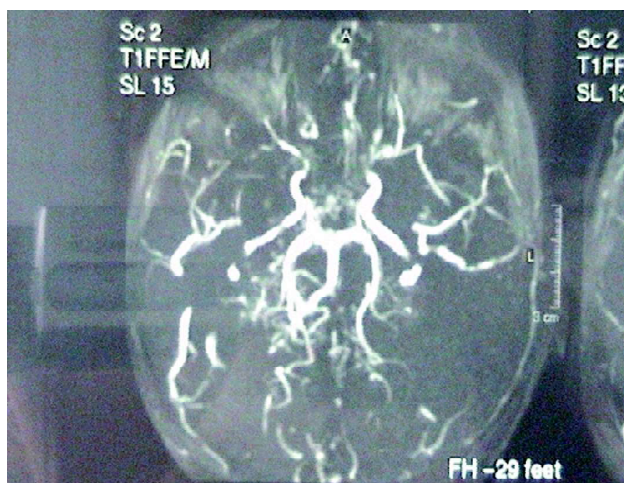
MRI showing occlusion of the supraclinoid portion of both the internal carotid arteries.
